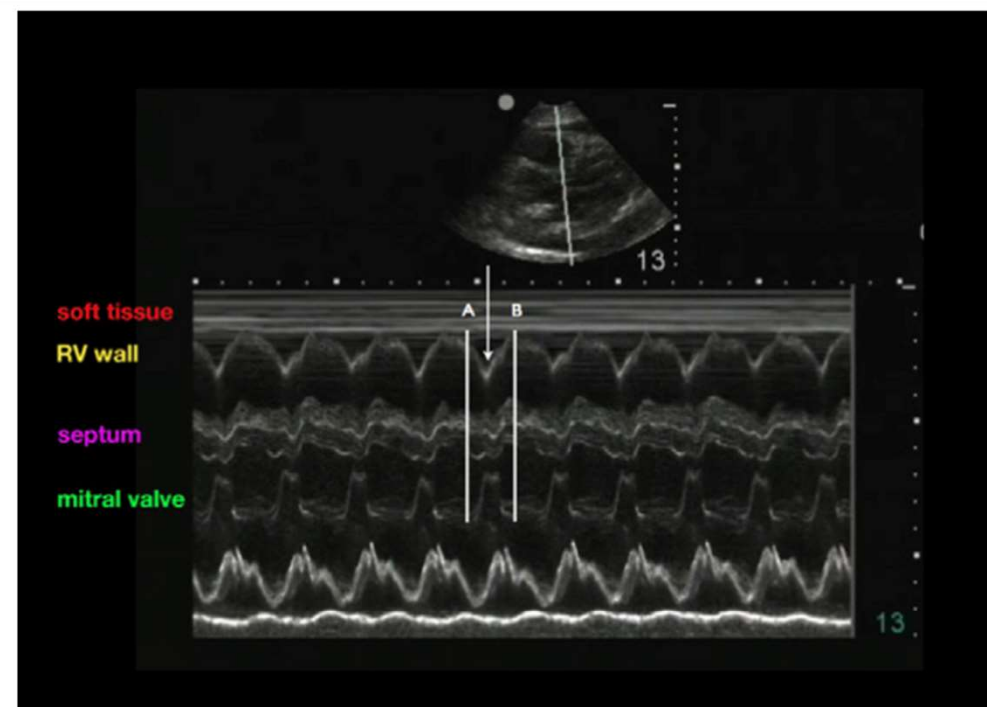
M-mode image obtained from parasternal long orientation. Diastole, with associated mitral valve opening and right ventricular free wall collapse, occurs between the A and B. The arrow represents the abnormal posterior wall motion of the right ventricular free wall in early diastole.
